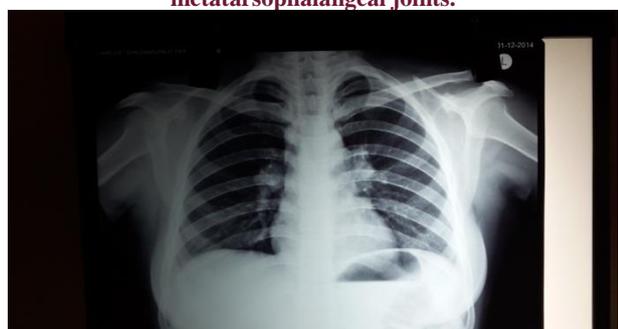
Chest X-ray showing nodular opacities bilaterally in mid-zones.
